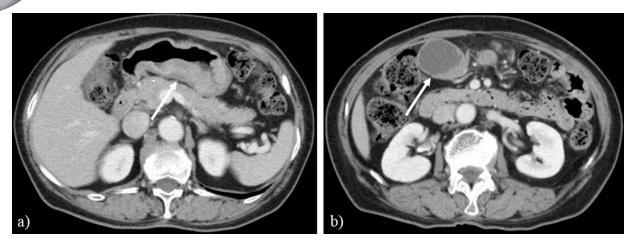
(Case 3) Abdominal contrast-enhanced computed tomography before neoadjuvant chemotherapy. *a*, Wall hypertrophy was detected from the antrum to the angle involving the posterior wall (*arrow*). *b*, The No.6 lymph node was enlarged (*arrow*).
